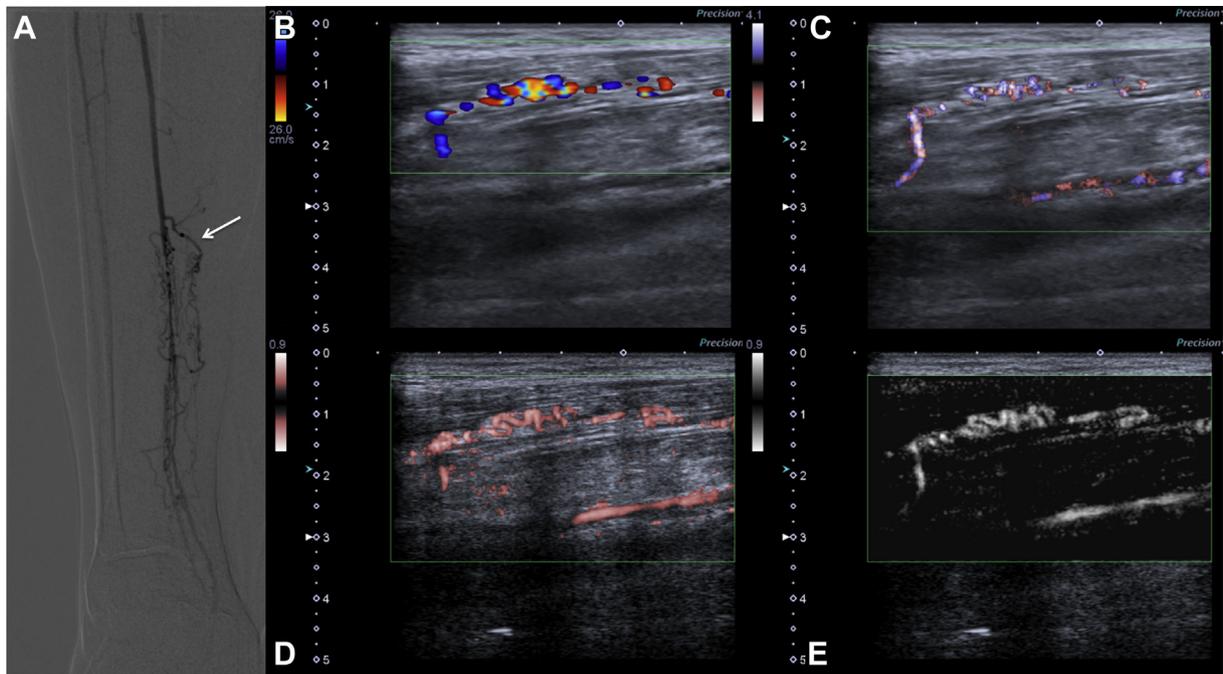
(A) Digital subtraction angiography shows corkscrew-like collaterals (arrow) originating from the distal one third of posterior tibial artery. (B-E) All ultrasound images were acquired with the Toshiba Aplio 500 ultrasound system (Canon Medical Systems, Tokyo, Japan) using the same 10-14 MHz linear transducer. (B) Color Doppler imaging (transducer frequency: 14 MHz, 12 frames per second [FPS]) of the same region is suggestive of underlying collateral vessels; however, depiction of the exact course of vessels is not possible due to the exaggerated flow signal. (C) Advanced dynamic flow image (transducer frequency: 14 MHz, 7 FPS) demonstrates a more clear delineation of corkscrew vasculature. (D, E) Color and monochrome superb microvascular images (transducer frequency: 14 MHz, 27 FPS) are superior in demonstration of corkscrew collaterals with a much better resolution.
